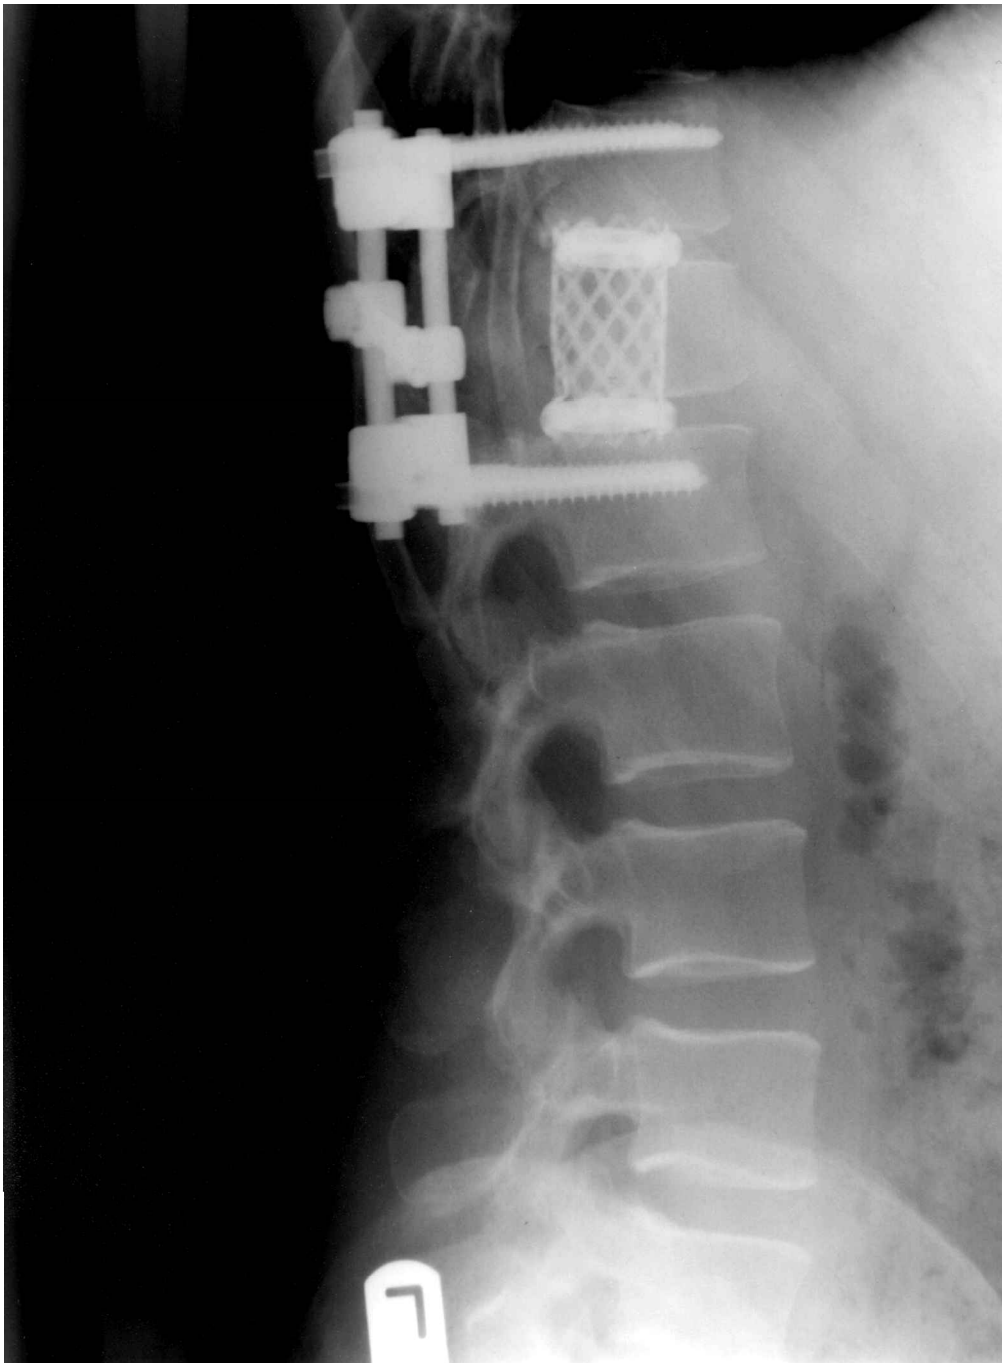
Post-operative X-ray showing the position of the implants.
